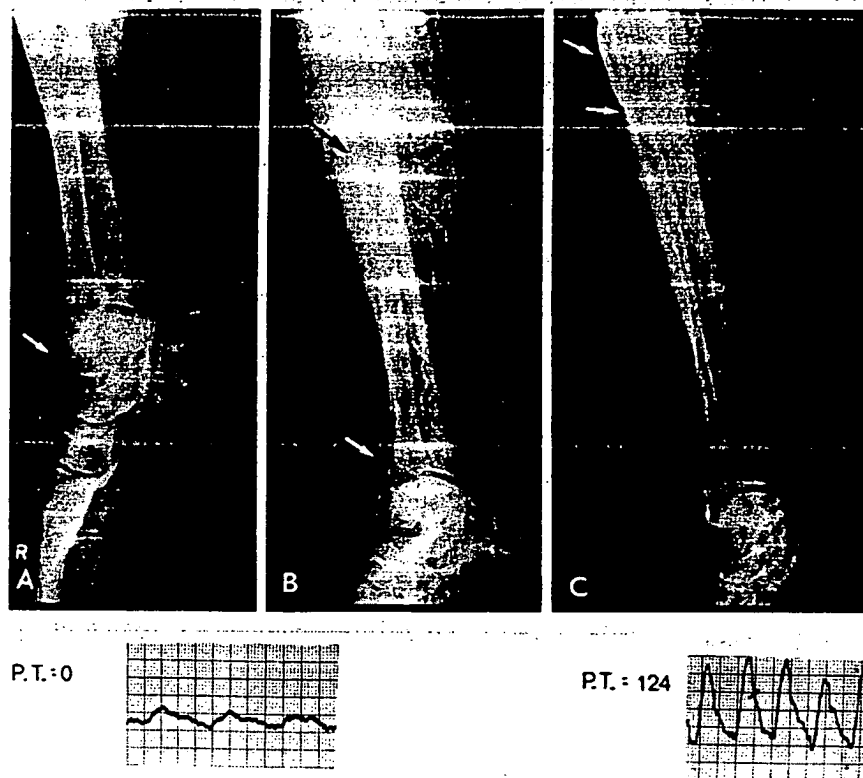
Doppler flow detection in femorodistal bypass. *A*, Although the tibial vessels did not fill on arteriography, the Doppler instrument detected pulsatile flow over the dorsalis pedis artery (arrow). *B*, The intraoperative, prebypass arteriogram confirmed the presence of a patent anterior tibial artery (arrows). *C*, Note the change in pulsatile flow patterns after a successful femoral-anterior tibial bypass (arrows).
